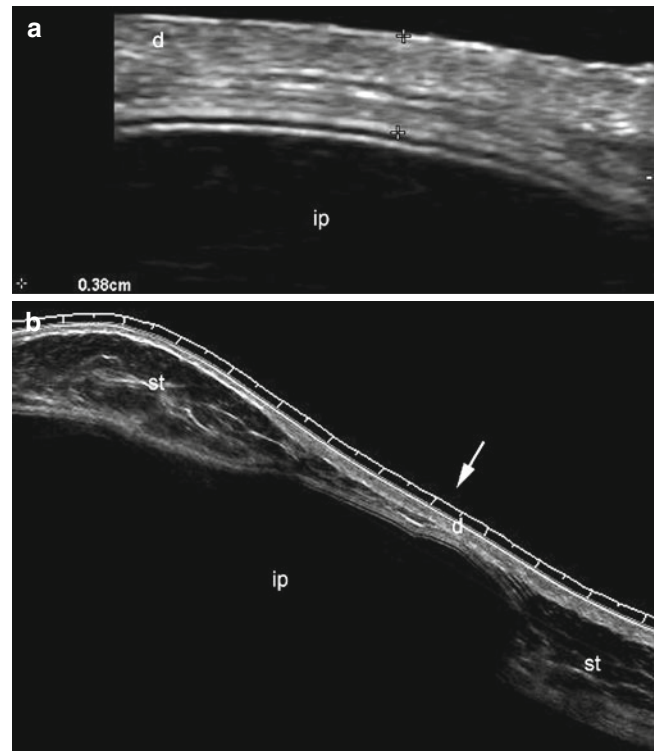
(a, b) Breast implant. (a, b) Grey scale ultrasound images (longitudinal views; a zoomed image; b extended field of view) show a region with atrophy of the subcutaneous tissue (arrow) and almost direct contact between the anechoic well-defined silicone implant (ip) and the dermis. The distance between the epidermal layer and the implant is 3.8 mm in this location. The patient presented with erythema in the same region. *Abbreviations:* d dermis, st subcutaneous tissue
